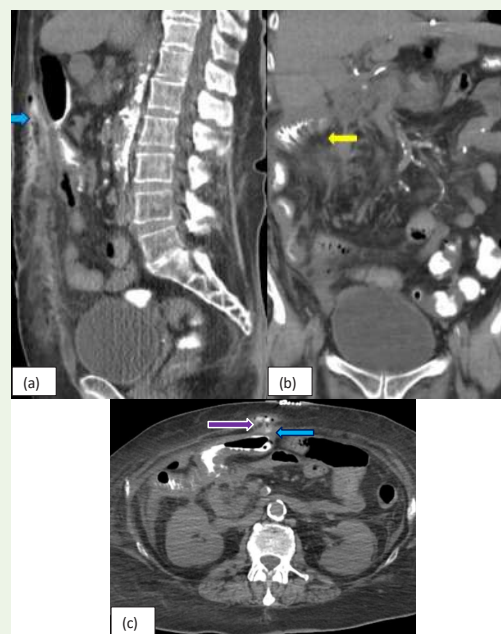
(a, b, c, d): Coronal and Axial CT images of a 59-year-old female, post right colectomy presents with acute pain abdomen. CT scan of the abdomen and pelvis with rectal contrast shows extra-luminal contrast (blue arrow) in the entire peritoneal cavity and air (red arrow) adjacent to the ascending colon, suggestive of an anastomotic leak. Also, Small bowel ileus/partial small bowel obstruction with diffuse mesenteric fat stranding (yellow arrow) is noted.
